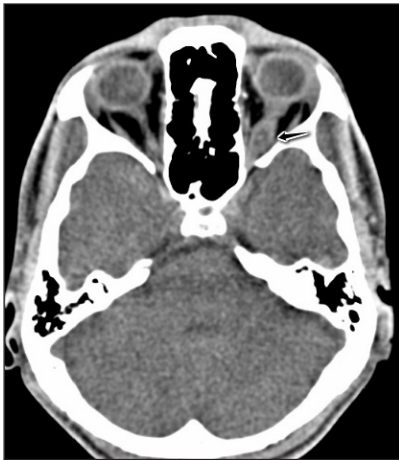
Axial CT section in a 21-year-old patient at the level of optic nerve showing a cyst with mural nodule in the mid portion of left optic nerve (arrow). CT: Computed tomography
